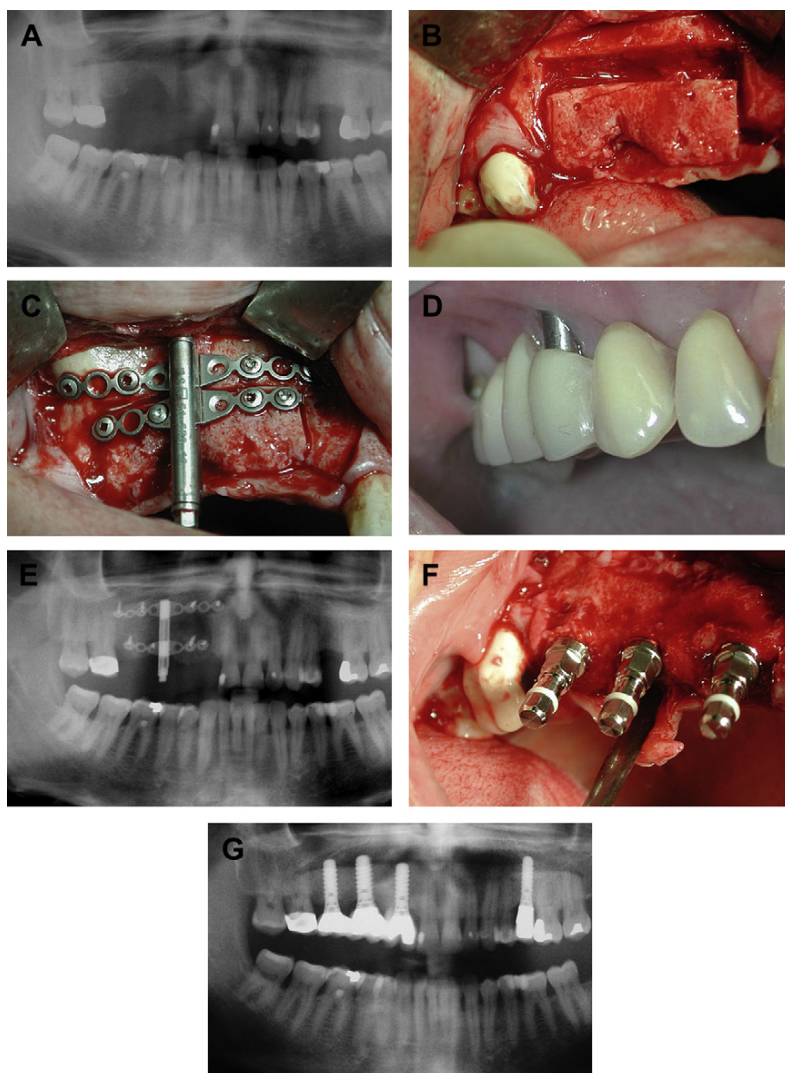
Alveolar reconstruction using alveolar distraction in preparation for dental implants. (A) Right maxillary posttraumatic vertical defect. (B) Osteotomy. (C) Alveolar distractor in place. (D) Vector control using a prosthesis. (E) Panoramic radiograph after the end of the distraction. (F) Placement of dental implants. (G) Panoramic radiograph at the end of the treatment.
